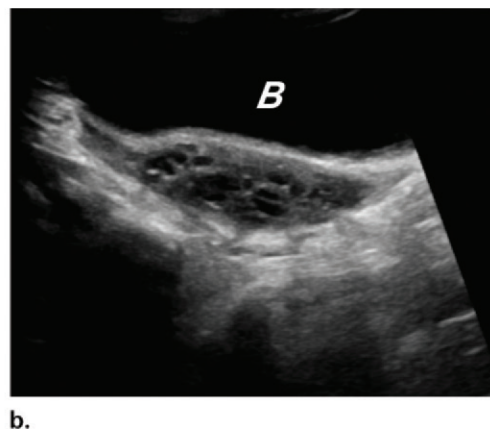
Ovarian torsion in a 6-year-old girl with right lower quadrant pain and vomiting. B = urinary bladder. (a) Sagittal gray-scale US image shows prominent peripheral follicles (arrows) in an enlarged right ovary with a volume of 15.3 cm³. (b) Sagittal gray-scale US image shows normal follicles interspersed within a normal left ovary, which has a volume of 6.4 cm³. (c) Transverse power color Doppler US images of the right ovary (RO, white arrow) and left ovary (LO, black arrow) show relatively decreased flow in the right ovary compared with the flow seen in the contralateral ovary. Right ovarian torsion was found at surgery.
